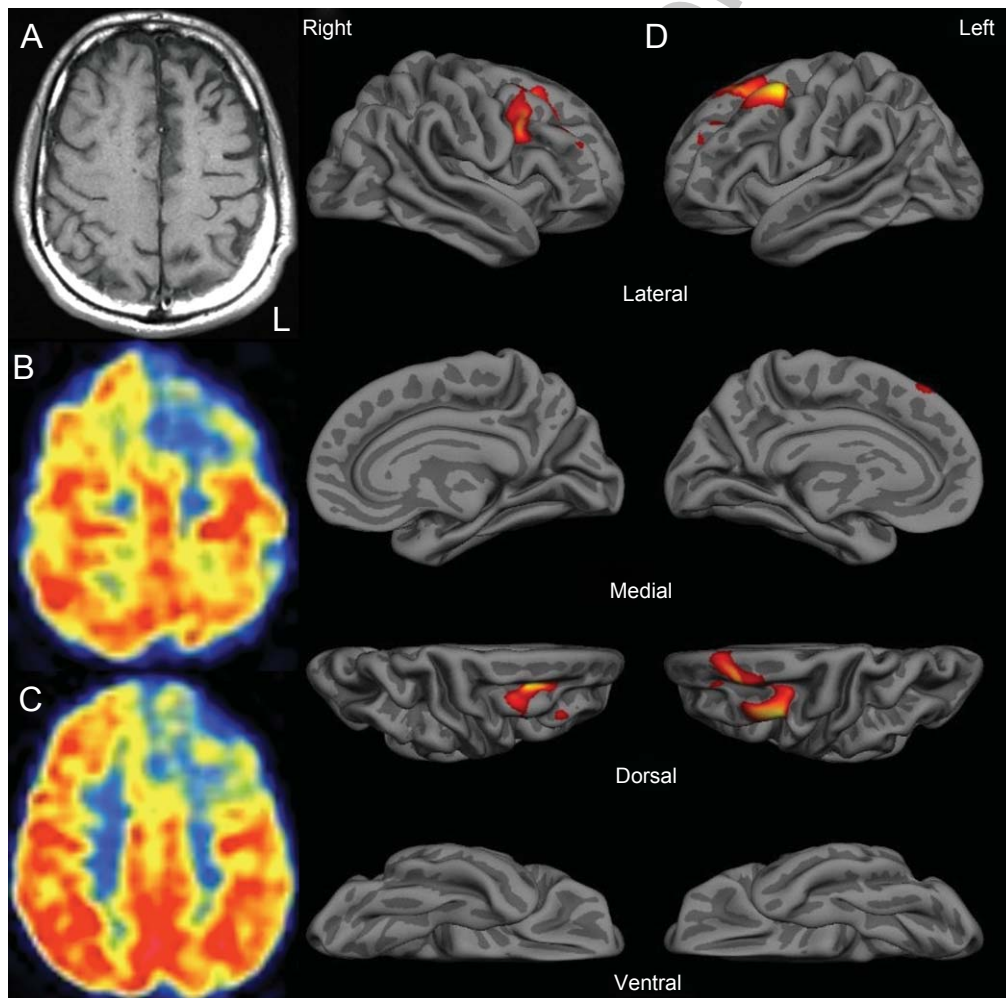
Left lateralized frontal atrophy and hypometabolism. A) T1-weighted MRI demonstrating mild left anterior frontal atrophy. B, C) FDG-PET showing left anterior frontal hypometabolism. D) Quantitative cortical thickness analysis. Focal cortical thickness reductions (red on color map) occurred in left > right superior and middle frontal gyri. L indicates left.
